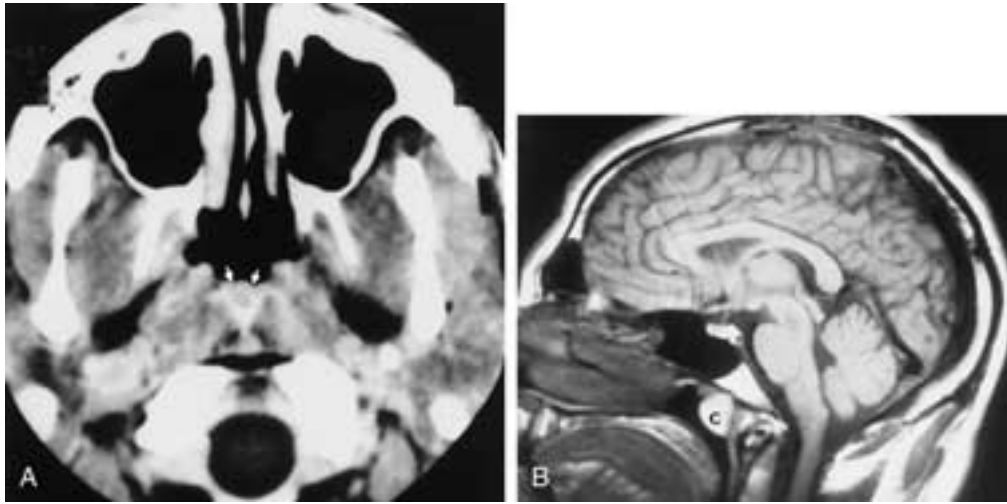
Tornwaldt's cyst. A, CT scan through the upper nasopharynx demonstrates a midline Tornwaldt's cyst (arrows). Note that its density is similar to that of the surrounding muscle. The high density of this cyst is probably related to its high protein concentration. B, Sagittal T1-weighted MR scan through the upper nasopharynx demonstrates a high signal intensity Tornwaldt's cyst (c). The high intensity is due to the high protein concentration within the cyst. This shortens the T1 relaxation time sufficiently to produce increase in intensity on T1-weighted images.
